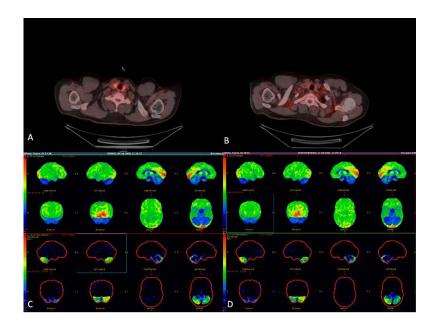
[¹⁸F]FDG PET-CT scan. Axial section showing diffusely increased metabolic activity in both lobes of thyroid that decreased significantly in post thyroid hormone replacement treatment images (A and B). Brain imaging showing Hypometabolism in cerebellar region with partial improvement in post thyroid hormone replacement treatment images (C and D).
